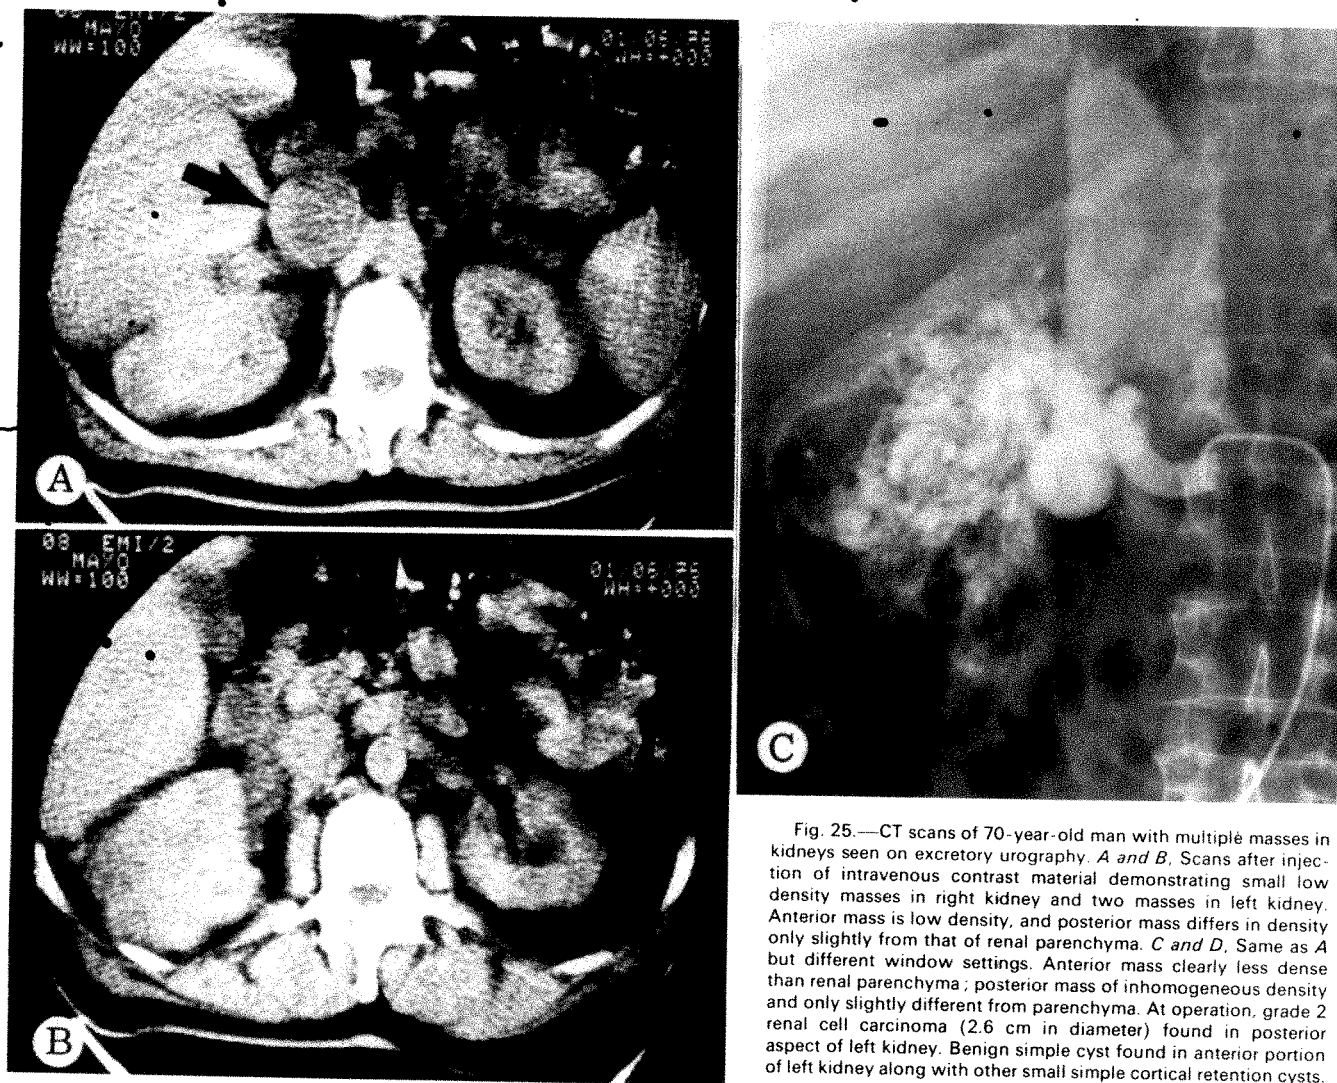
CT scans of 70-year-old man with multiple masses in kidneys seen on excretory urography. *A and B*, Scans after injection of intravenous contrast material demonstrating small low density masses in right kidney and two masses in left kidney. Anterior mass is low density, and posterior mass differs in density only slightly from that of renal parenchyma. *C and D*, Same as *A* but different window settings. Anterior mass clearly less dense than renal parenchyma; posterior mass of inhomogeneous density and only slightly different from parenchyma. At operation, grade 2 renal cell carcinoma (2.6 cm in diameter) found in posterior aspect of left kidney. Benign simple cyst found in anterior portion of left kidney along with other small simple cortical retention cysts.
